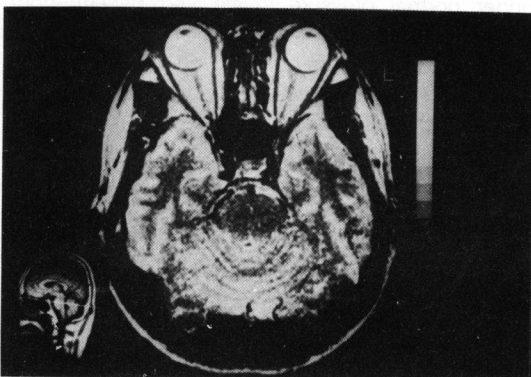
MRI scan shows no abnormal findings (TR/TE 200/112)
